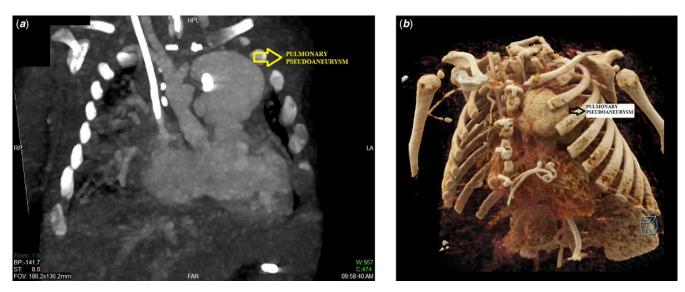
(a) Contrasted CT indicating giant pulmonary pseudoaneurysm and vicinity of it to the sternum. (b) 3D reconstruction of the tomography.
